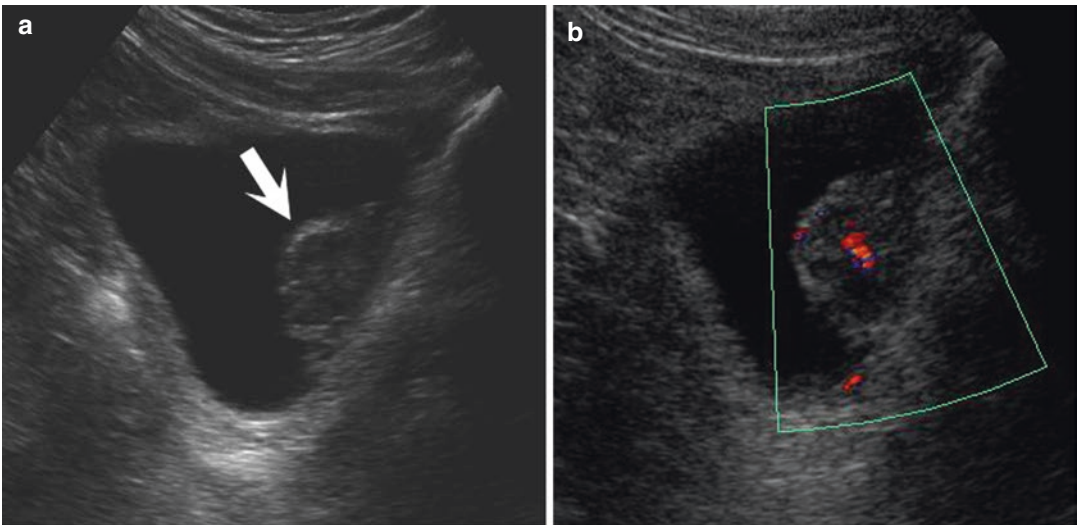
Bladder cancer. The tumor appears as papillary hypoechoic masses (a). At color Doppler, the flow within the mass is appreciable, allowing the differentiation with a clot (b)
